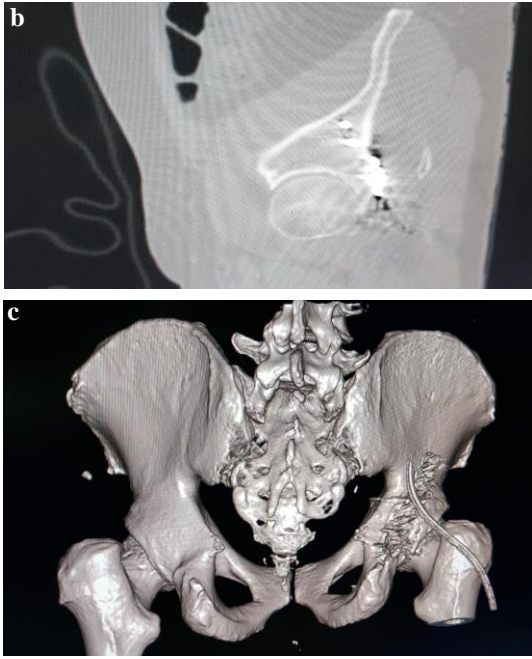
Postoperative CT scan a. axial, b. sagittal and c. 3D reconstruction of both hips shows reduction of Rt acetabular fracture with fixation.
